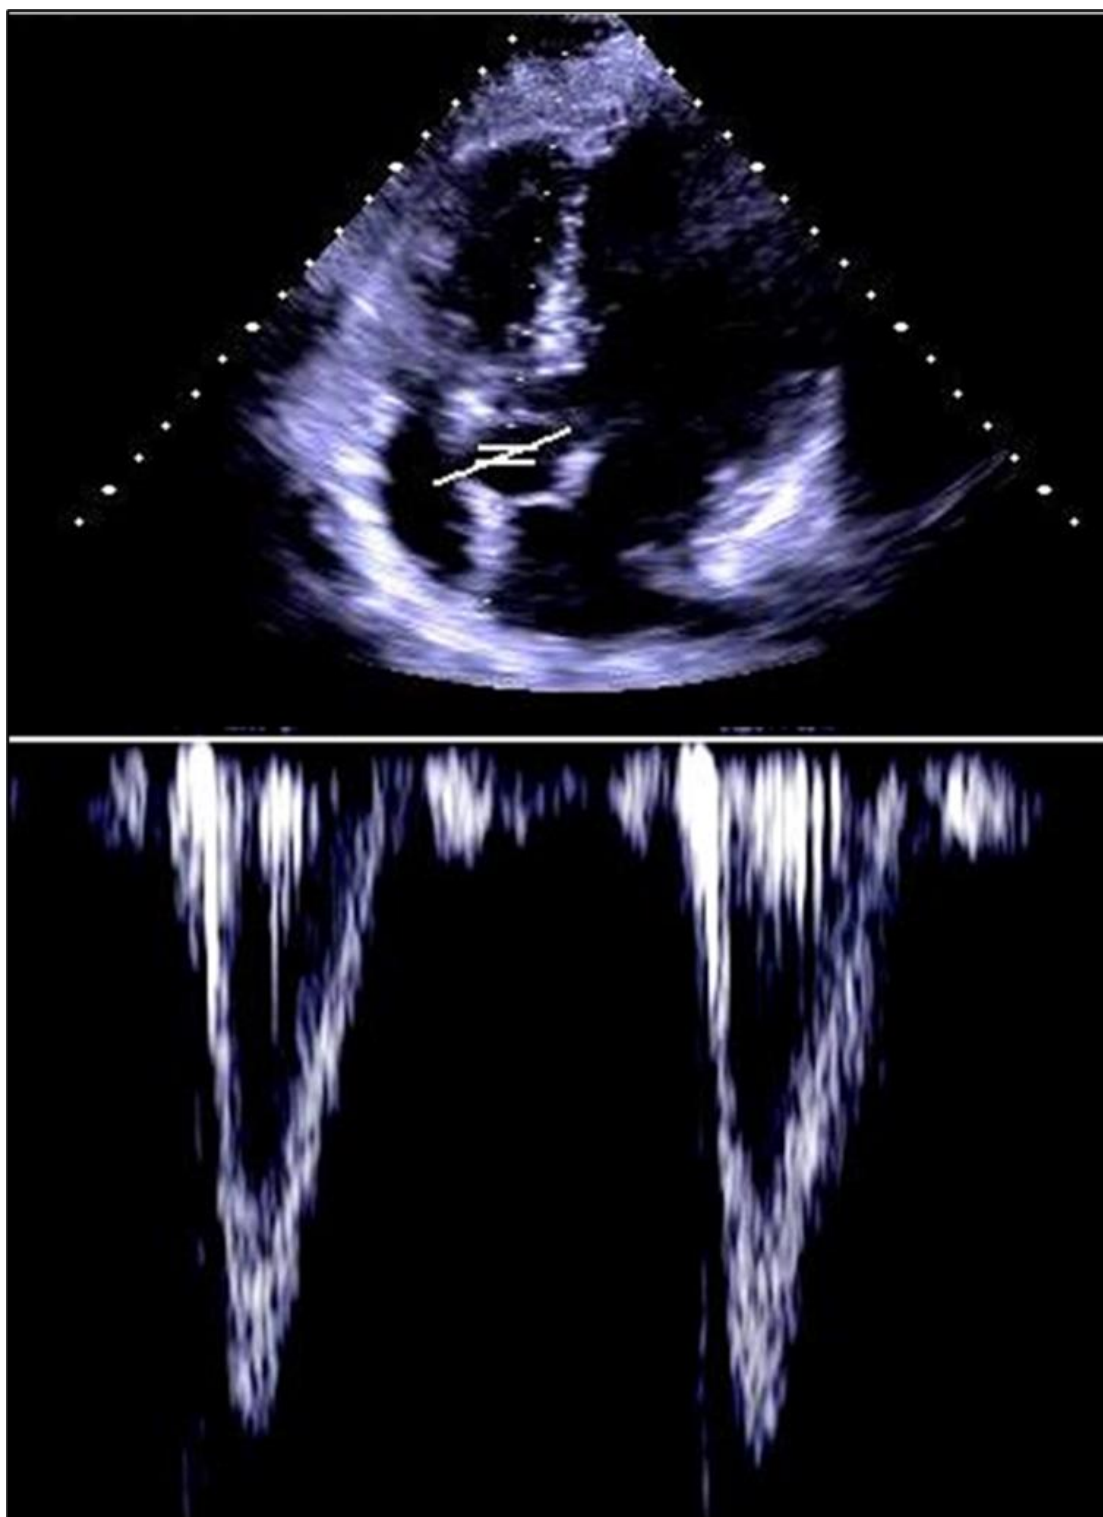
Aortic velocity waveforms (lower panel) obtained in the apical five-chamber view (upper panel) of the heart.
